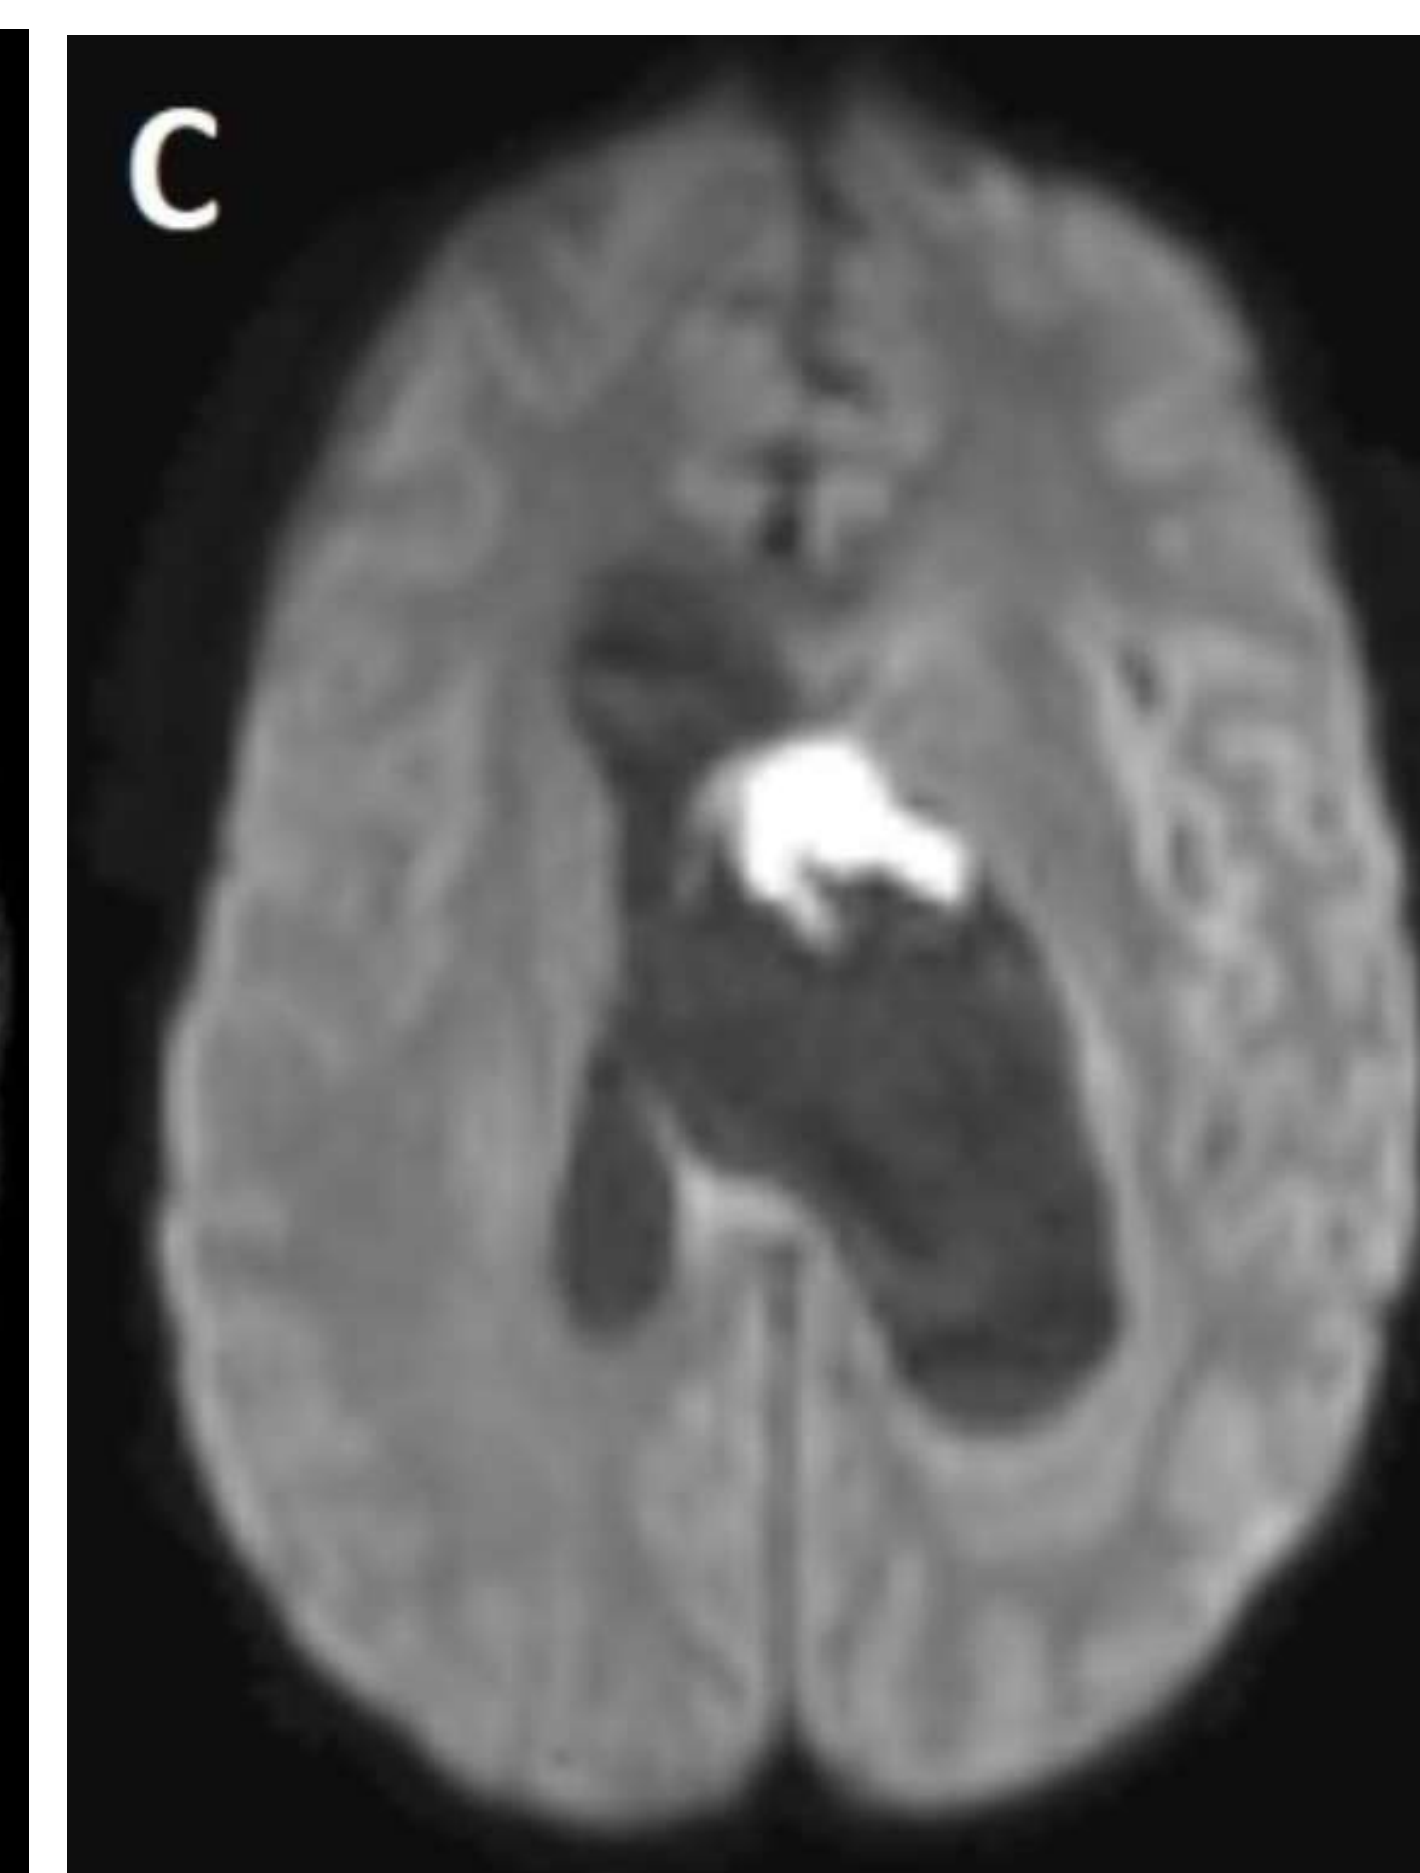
Axial MR diffusion-weighted sequence demonstrates a region of homogenous restricted diffusion within the body of the left lateral ventricle corresponding to the location of the hyperintense FLAIR component.
